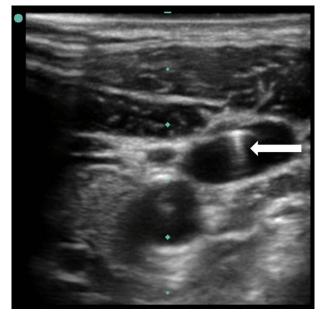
Ultrasound of the neck showing the relationship of the carotid artery (medial) and internal jugular vein (lateral). Needle entry into the vessel can be noted by the hyperechoic structure (arrow) within the internal jugular vein.
